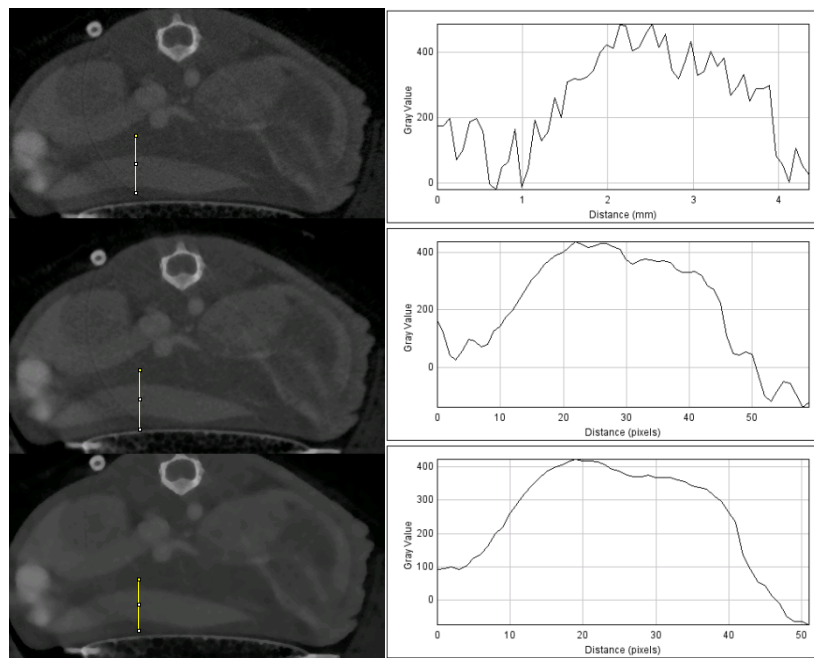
Axial CT slices (left) and line profiles (right), before bilateral filtration (top), and after filtration using a filter with width of 1 pixel (middle) and 5 pixels (bottom).
